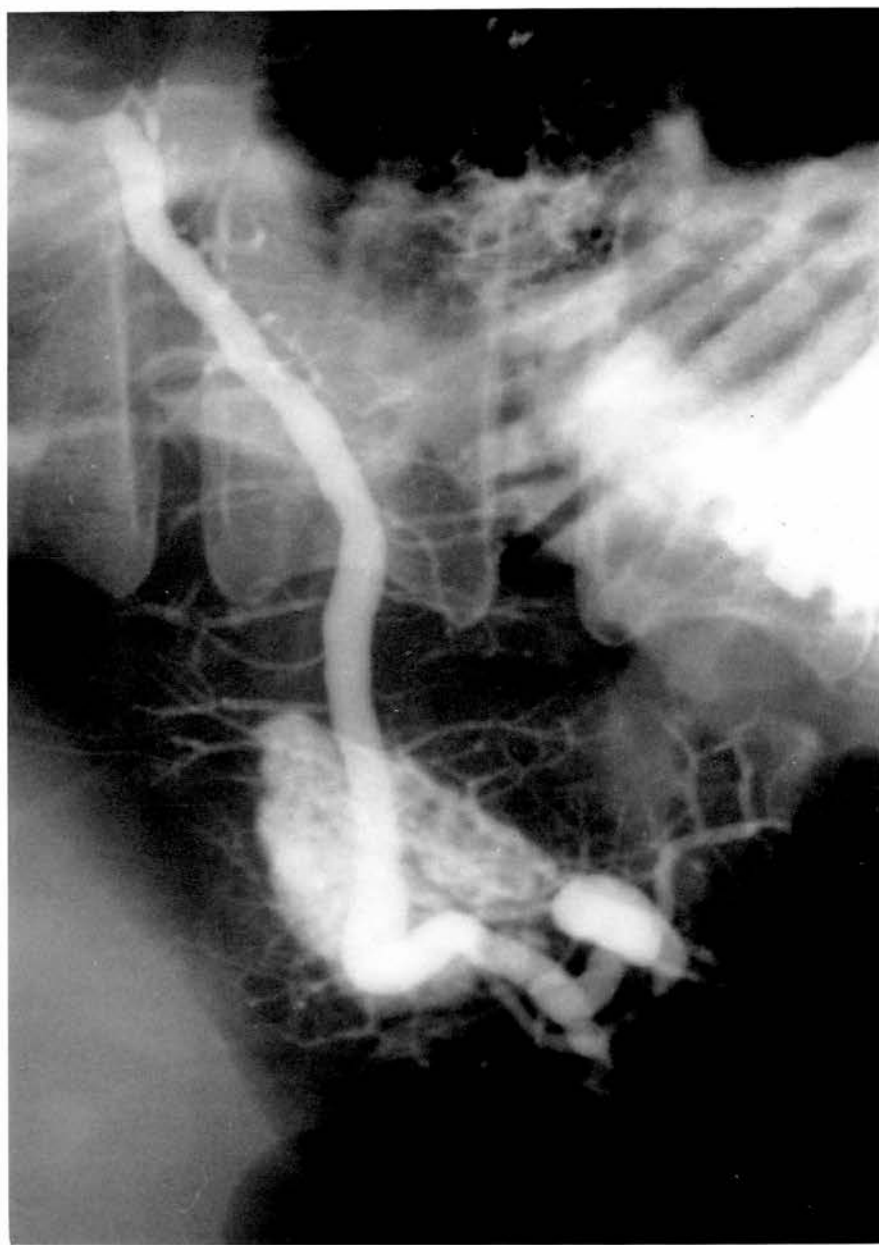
ERCP radiograph. Note acinar filling and duct rupture in head of gland.
